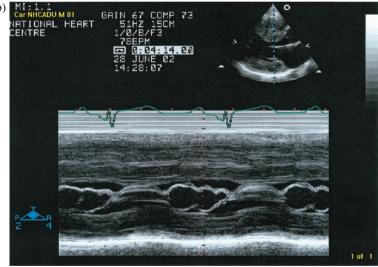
a) Zoom parasternal long axis view of the mitral valve showing systolic anterior motion (SAM) of the mitral valve. b) M-mode of the left ventricle at the level of the mitral valve demonstrating systolic anterior motion (SAM) of the mitral valve.
